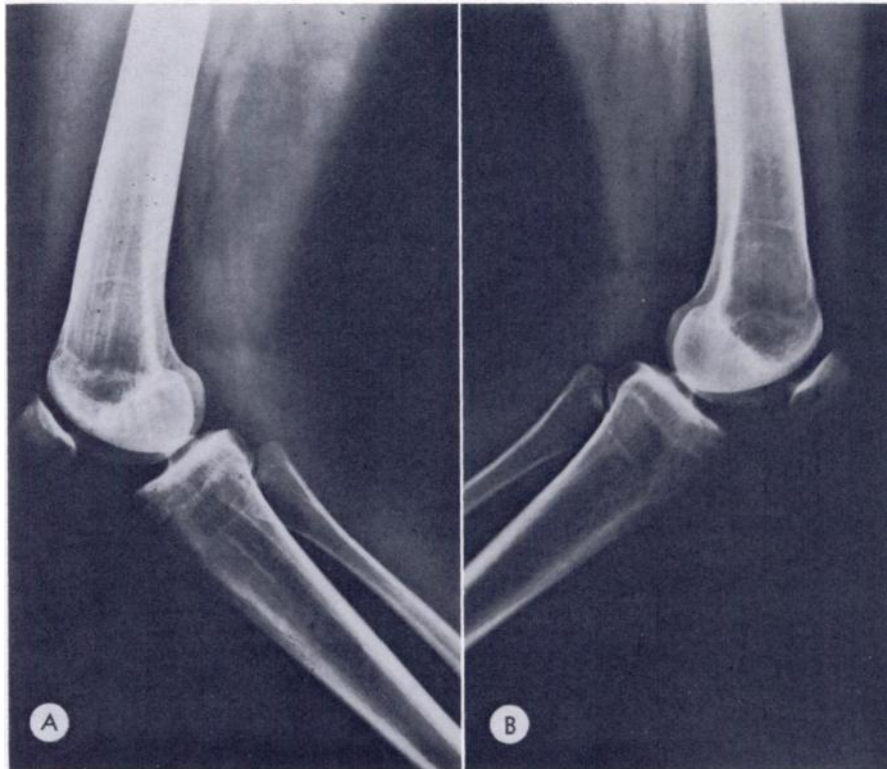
Case II. (A and B) Lateral roentgenograms of the knee joints show striations in the femur, tibia and fibula on the right. The left side is normal (B).
